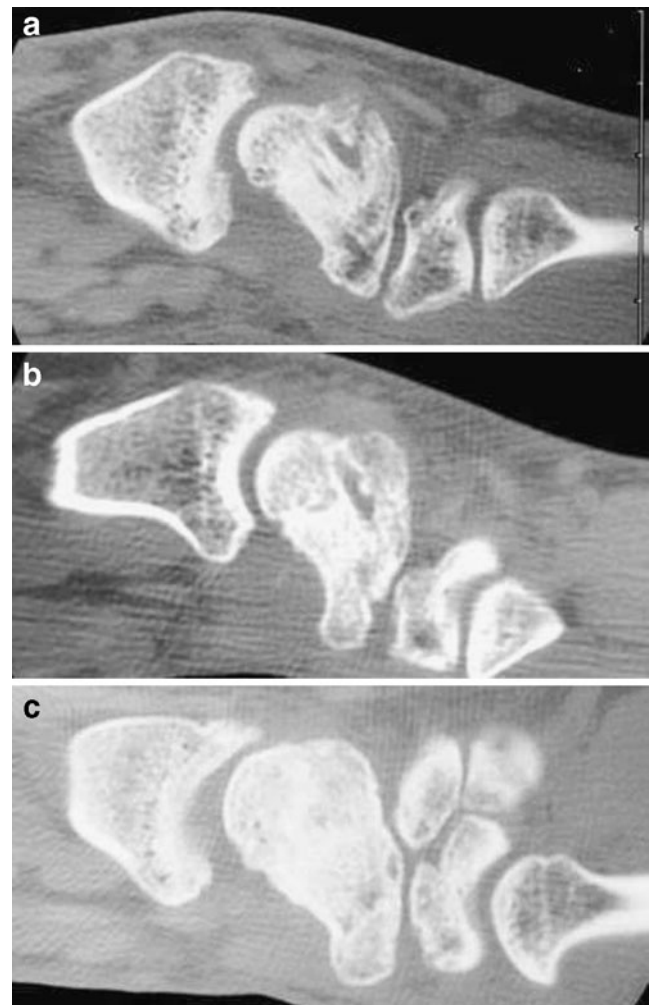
Twenty-three-year-old male. Serial CT scans demonstrating progressive remodeling of scaphoid at sequential time points following surgery. a 6 months. b 8 months. c 33 months.
